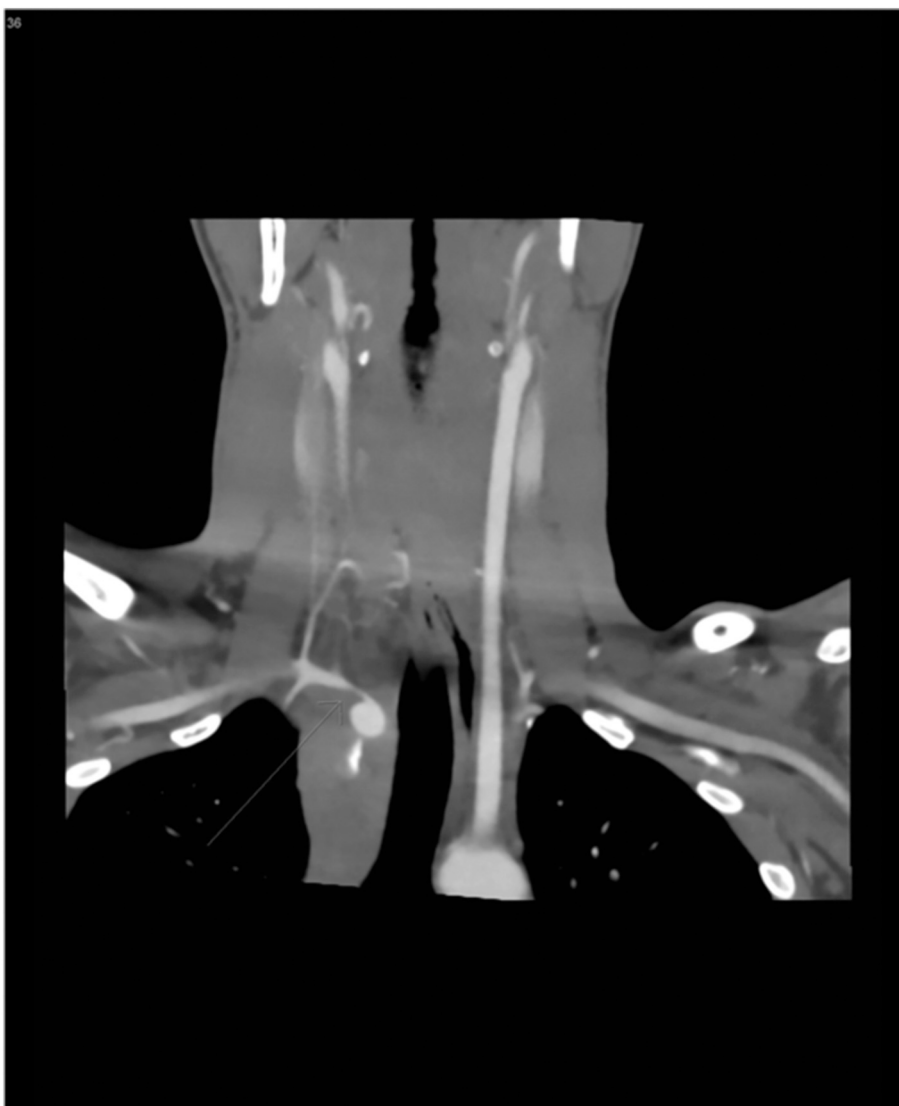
Initial CT scan of right physeal fracture/posterior dislocation – mass effect on upper mediastinum including vasculature and trachea.
